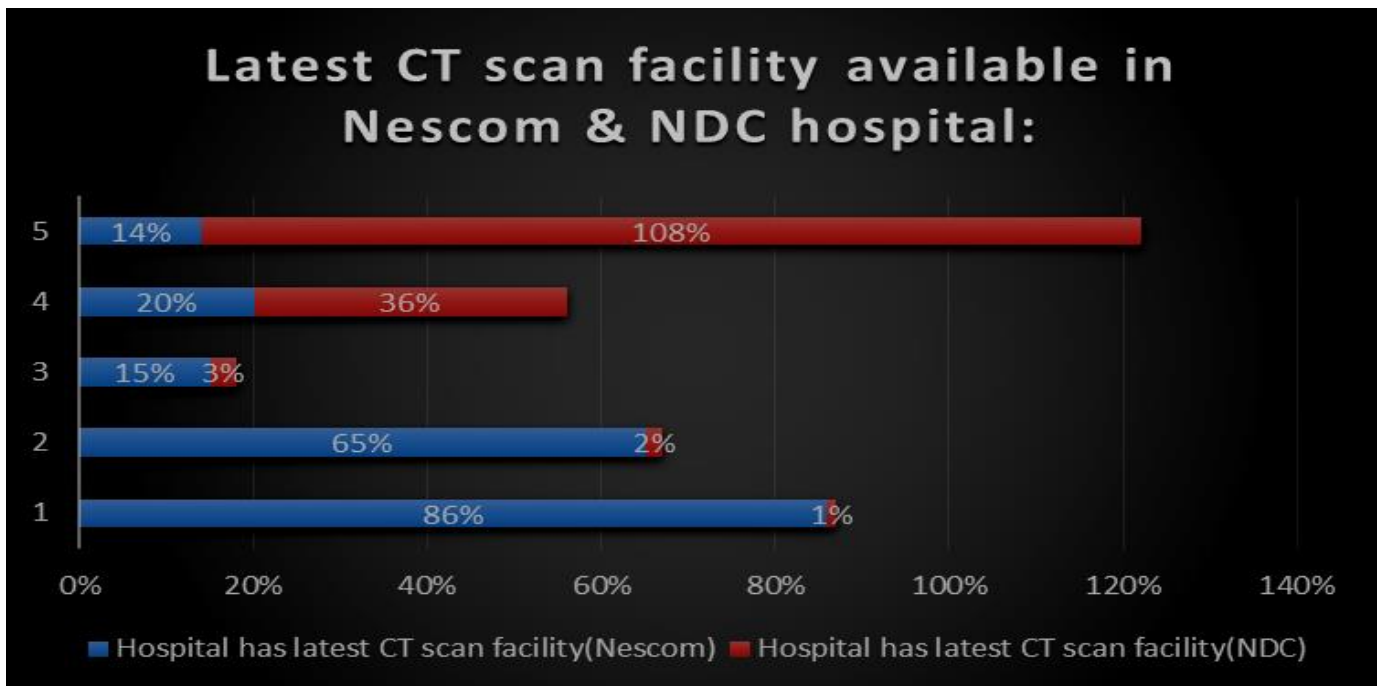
Had hospital latest CT scan facility:
